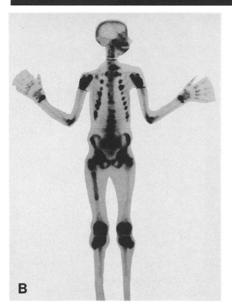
A An AP radiograph of the right femur demonstrates a dominant sclerotic lesion in its proximal half. B A 99mTcMDP bone
